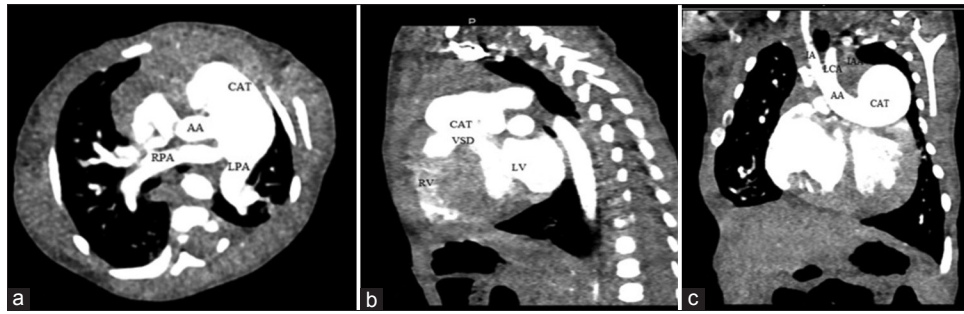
(a) Axial section of computed tomography showing CAT with origin to ascending aorta as a side branch from the right side and also origin of both pulmonary arteries from the posterior aspect of CAT. (b) Sagittal view showing overriding of CAT with RV predominance. (c) Coronal view showing origin of hypoplastic ascending aorta from CAT with Type B IAA. RV: Right ventricle, LV: Left ventricle, CAT: Common arterial trunk, IAA: Interrupted aortic arch, IA: Brachiocephalic artery, LCA: Left common carotid artery, RPA: Right pulmonary artery, LPA: Left pulmonary artery
